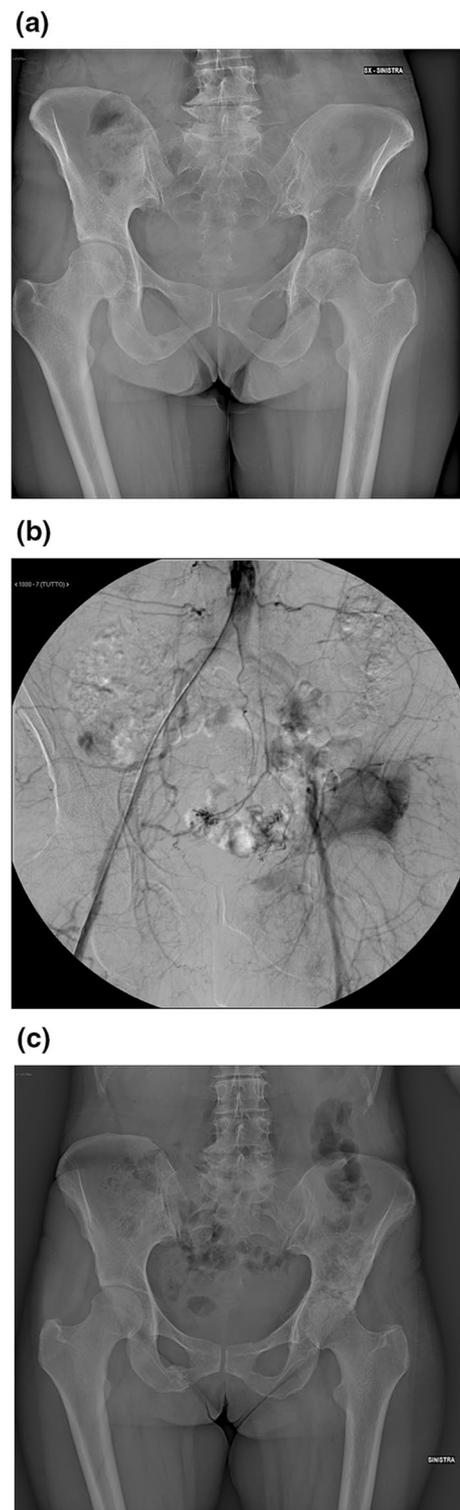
a Anteroposterior radiograph of the pelvis of a 60-year-old woman with a painful supra-acetabular bone metastasis from breast cancer. b Arteriography shows pathological vascularization originating from branches of the obturator and deep femoral artery. c Anteroposterior radiograph of the pelvis 24 months after embolization shows stable metastatic lesion with ossification
